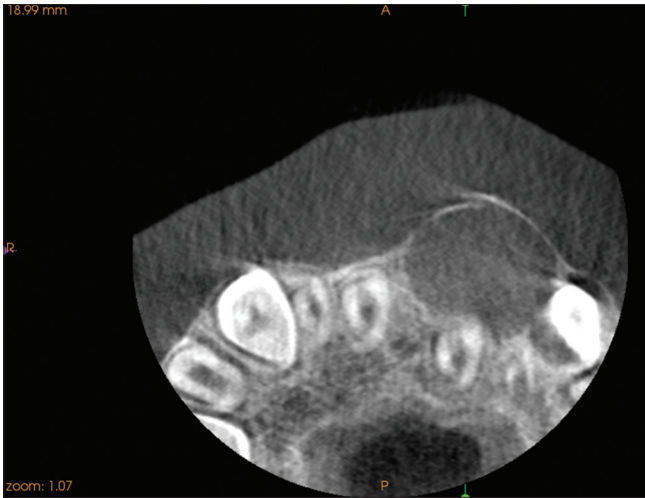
Cone-beam computed tomography showing unilocular radiolucency extending from the junction of the middle third and apical third of 21 up to the middle third of the crown
